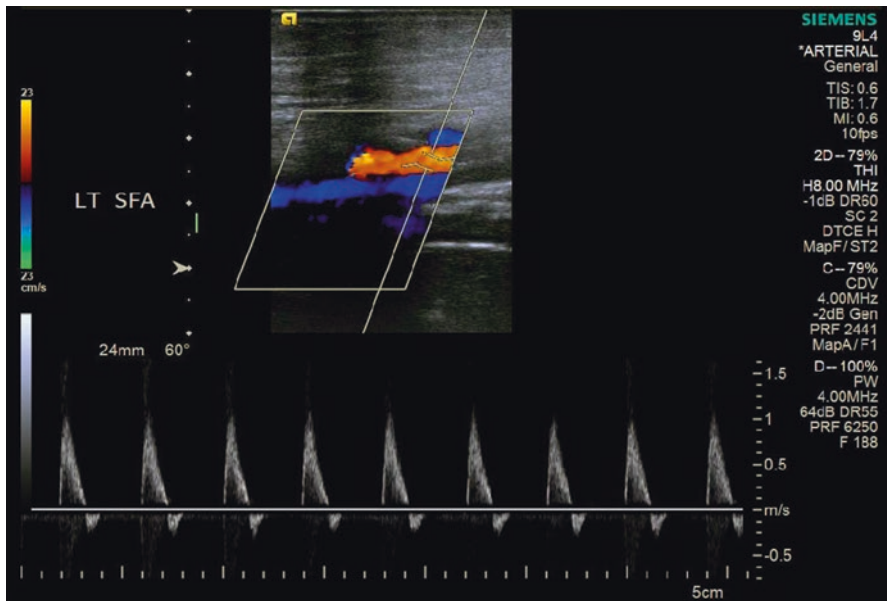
Duplex ultrasound of the left superficial femoral artery demonstrating normal triphasic flow in the artery (*arrow*) consistent with patency
